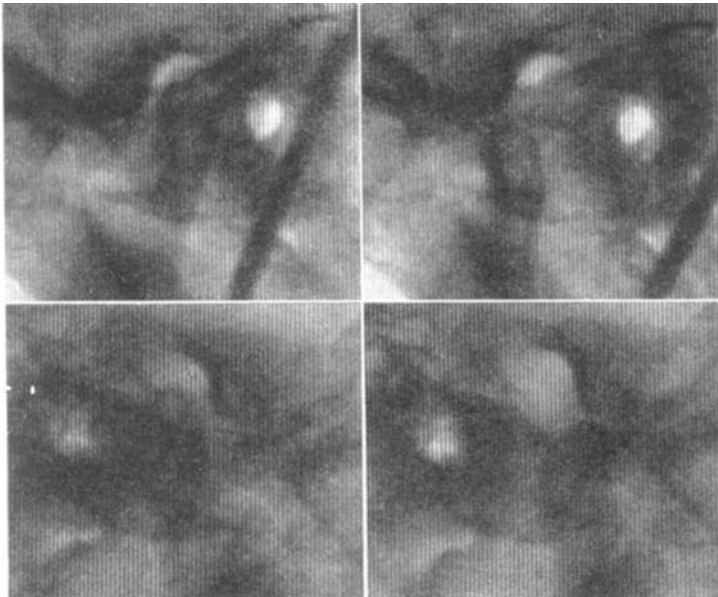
X-ray picture of left and right Temp. mand. joint in a normal bite, showing condyles in rest position and in maximal opening.
